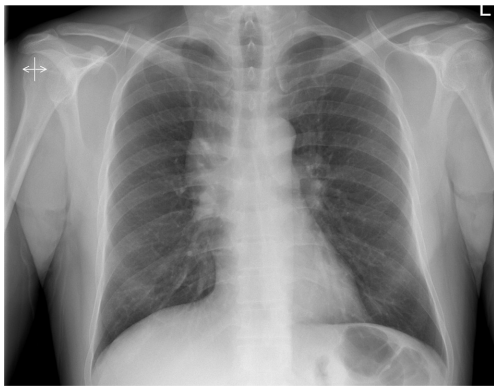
Chest X-ray of a 54-year-old man showing a mediastinal mass.
